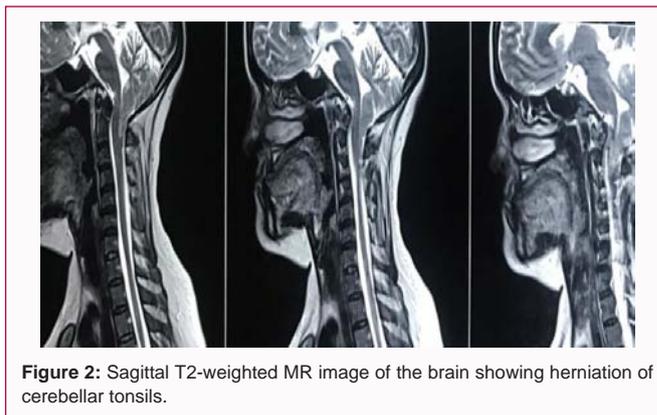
Sagittal T2-weighted MR image of the brain showing herniation of cerebellar tonsils.
